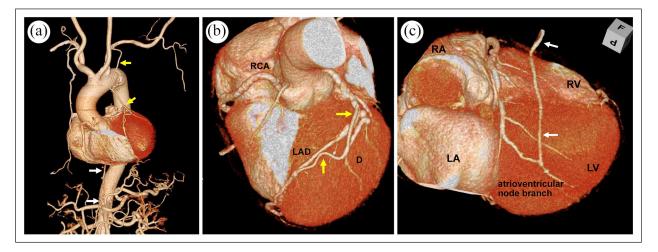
(a) Postoperative three-dimensional computed tomography. (b) All the bypass grafts were patent. (c) Yellow arrows indicate LITA and white arrows indicate RGEA.
